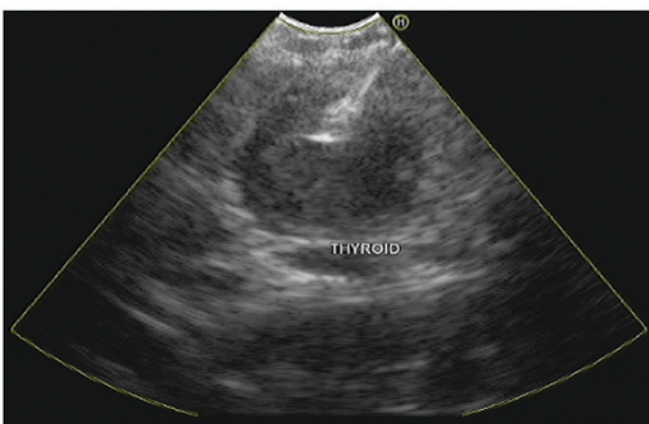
Endobronchial ultrasound transbronchial needle aspiration biopsy and drainage of the lesion in the right lobe of the thyroid.
